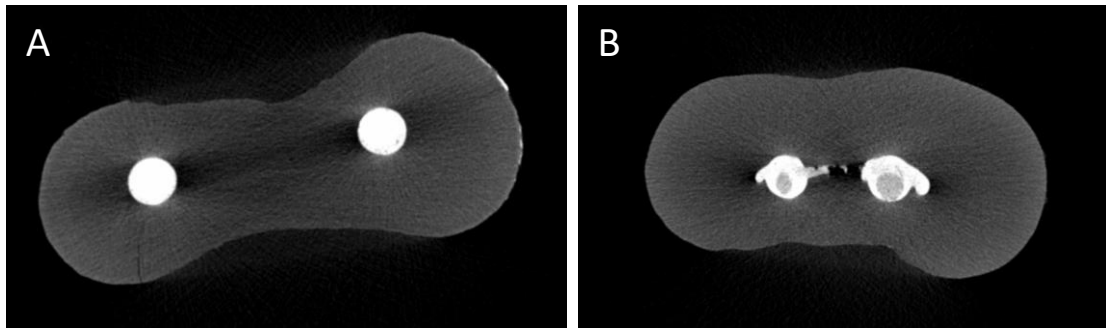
The μ CT images of filled natural molar; A: gap-free in round canals and B: gaps in an oval canal. The amount of filling materials inside the isthmus area were varies among the samples which result in high standard variation of the data
